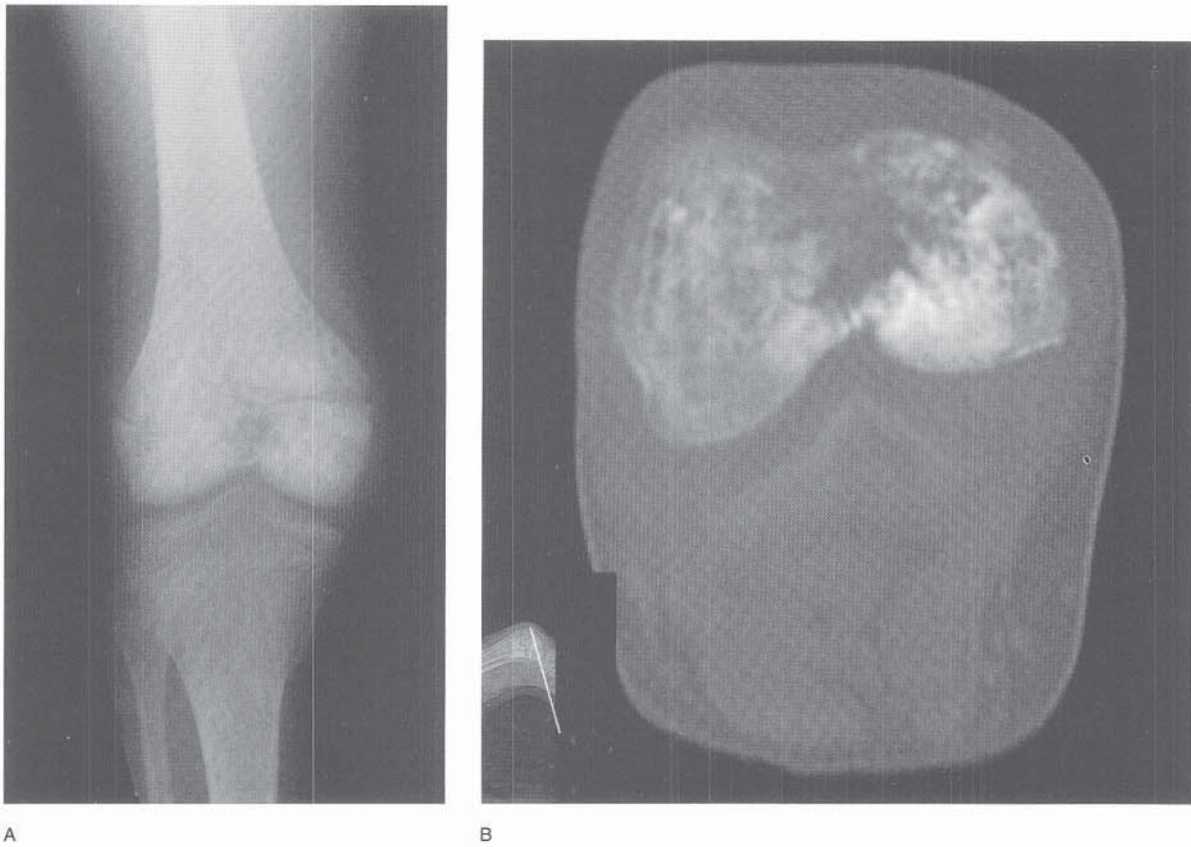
Imaging findings in a patient with osteosarcoma. A, A radiograph of the right knee shows osteoblastic and lytic regions within the distal femoral metaphysis and epiphysis. B, A transaxial CT image of the distal femoral epiphysis reveals the osteoblastic and lytic areas of bony destruction to better advantage.
